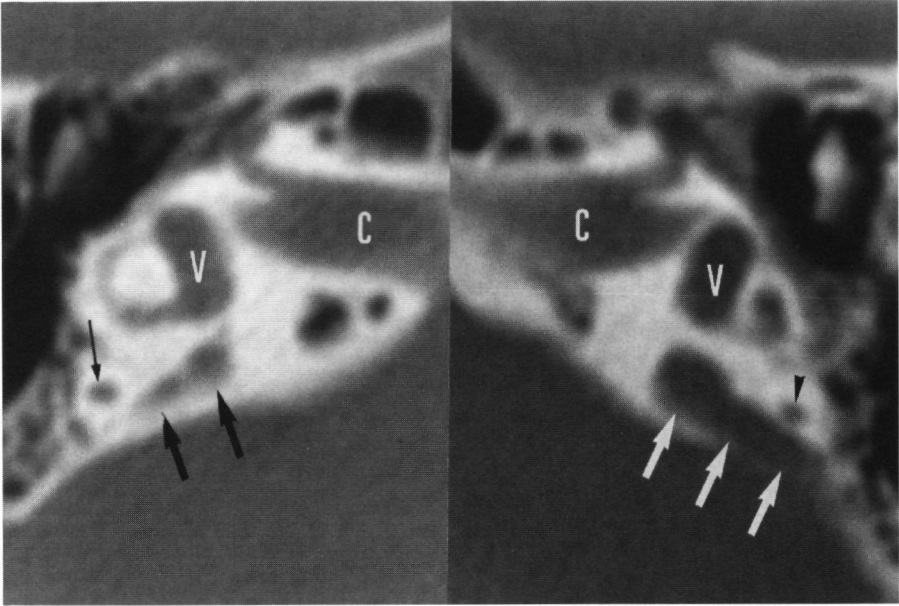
Patient III-4, bilateral large vestibular aqueduct. Axial CT image made at the level of the right and left vestibule. The right (large black arrows) and especially the left (large white arrows) vestibular aqueduct is enlarged and is much wider than the right (long black arrow) and left (black arrowhead) posterior semicircular canal. Normally the width of the vestibular aqueduct is smaller than the diameter of the posterior semicircular canal in the axial plane. Vestibule (V), internal auditory canal C.
